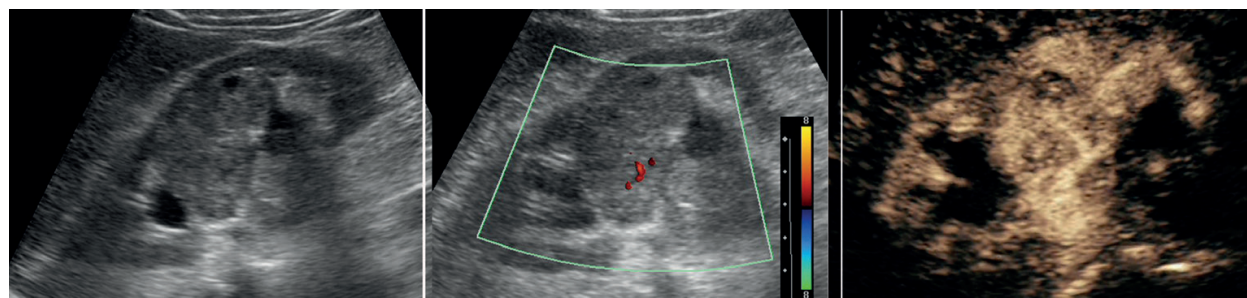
(a–c) Pseudotumor of the left kidney. In gray scale ultrasonography (a), there is a suspicion of a tumor in the middle of the organ. In Doppler color mode (b), there is a small vessel in the suspected tumor, insufficient for an accurate diagnosis. In CEUS focused on the middle of the kidney, there is no specific pattern for neoplasia.
